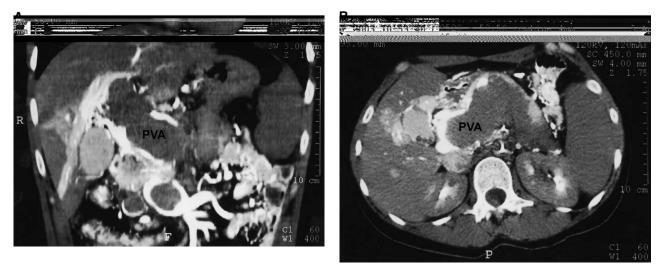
Preoperative helical computed tomography scan with contrast enhancement during the portal phase. A, Portal vein aneurysm (PVA) with acute complete thrombosis. B, Extension of the portal vein thrombosis into the aneurysmatic splenic vein and gallbladder with stones.
